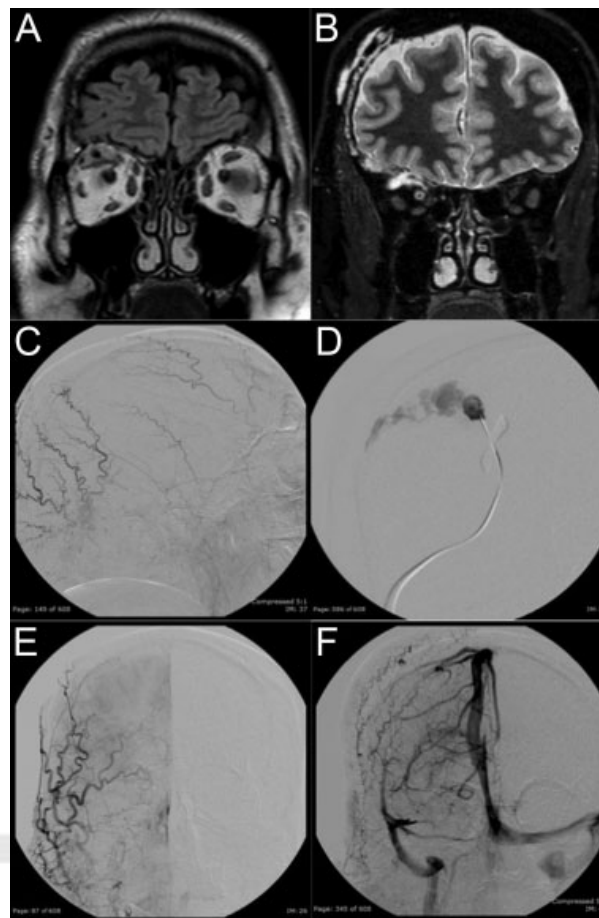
(a) Coronal fluid attenuation inversion recovery magnetic resonance imaging (MRI) showing the intraorbital part of the arteriovenous malformation (AVM) displacing the superior rectus muscle of the right eye. (b) Coronal short tau inversion recovery MRI showing the connection between the scalp AVM and the intraorbital part of the malformation. (c–f) Angiography demonstrates the feeders of the scalp AVM arising from the occipital artery and, to a lesser extent, from the superficial temporal artery.
